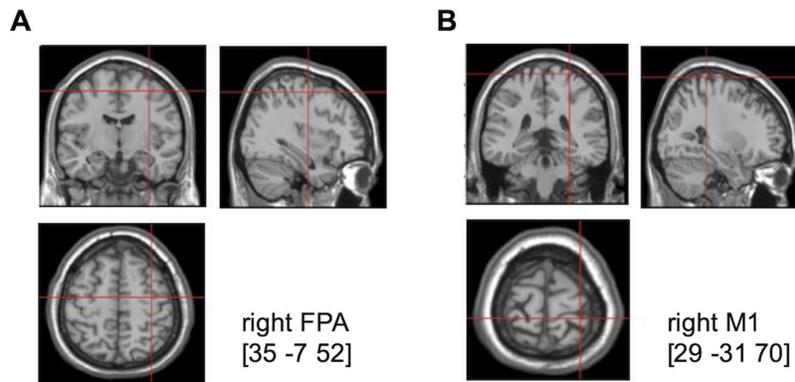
TMS stimulation sites. (A) The location of the right FPA (rFPA), [35 -7 52] in Talairach coordinate. (B). The location of the right primary cortex (rM1), [29 -31 70] in Talairach coordinate. The position was verified using individual MRI scan co-registered to their head landmarks using BrainSight software.
